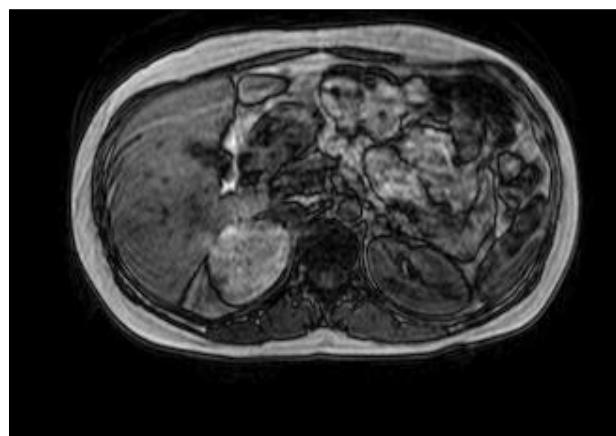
Magnetic Resonance Imaging of Phaeochromocytoma
